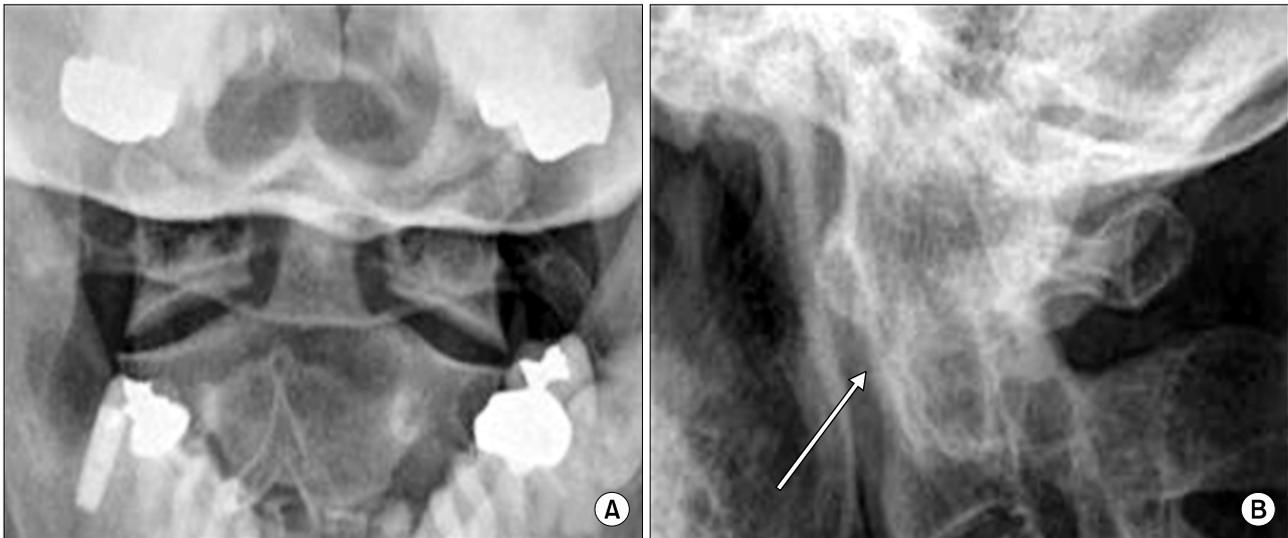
(A) A 33-year-old ankylosing spondylitis patient with duration of 8 years. An anteroposterior open-mouth view of the cervical spine reveals sparing of the atlantoaxial facet joint. (B) A lateral radiograph of the cervical spine with full flexion of the same patient shows ankylosis of anterior longitudinal ligament (arrow, component III).
